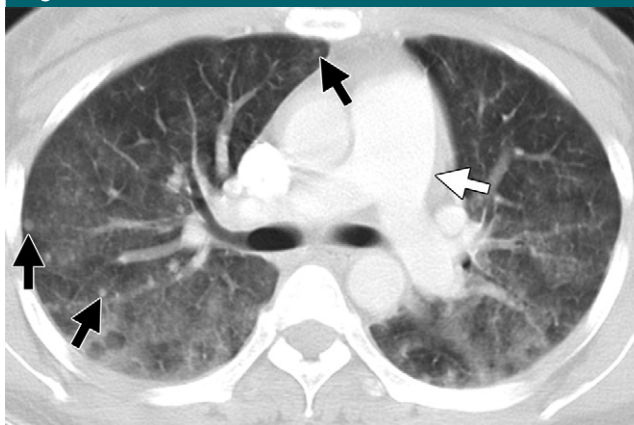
Axial (section thickness, 5.0 mm) CT image obtained at level of right upper lobar bronchus shows diffuse GGO lesions containing multiple small nodules (black arrows) in both lungs. Main pulmonary artery (white arrow) is enlarged and larger than ascending aorta, measuring 32 mm in diameter. Surgical lung biopsy results confirmed diagnosis of pulmonary IVL (Fig E2 [online]).
